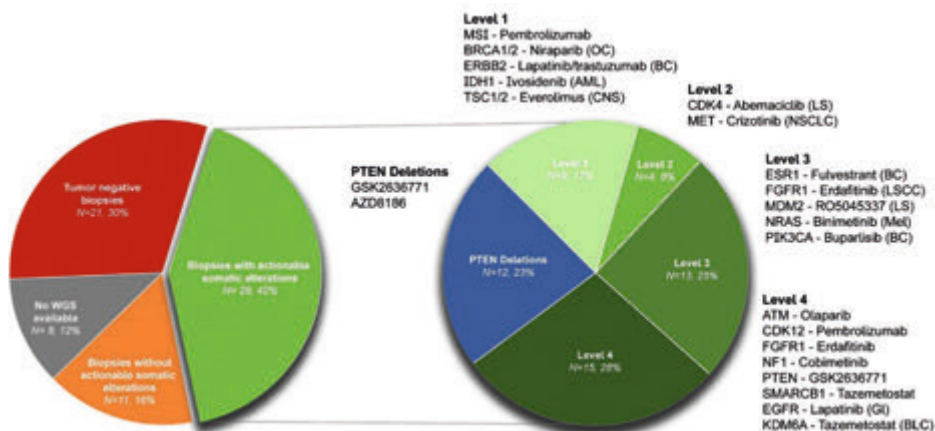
Actionable somatic alterations, detected by WGS, in ^{68}Ga -PSMA PET-guided bone biopsies from metastatic prostate cancer patients. Genes with actionable somatic alterations are categorized by level of evidence for targeted therapy as described in the OncoKB database. Evidence for both prostate cancer and other malignancies was combined within one category. Level 1: Food and Drug Administration (FDA)-recognized biomarker predictive of response to FDA-approved drug. Level 2: Standard-care biomarker predictive of response to FDA-approved drug. Level 3: Compelling clinical evidence supports the biomarker as being predictive of response to a drug. Level 4: Compelling biological evidence supporting biomarker as being predictive of response to drug. For every altered gene, example of targeted therapy suitable for specific alteration was described. WGS= whole genome sequencing, OC= ovarian cancer, BC= breast cancer, AML= acute myeloid leukemia, CNS= central nervous system cancer, LS= liposarcoma, NSCLC= non-small cell lung cancer, LSCC= lung squamous cell carcinoma, Mel= melanoma, GI= glioma, BLC= bladder cancer.
